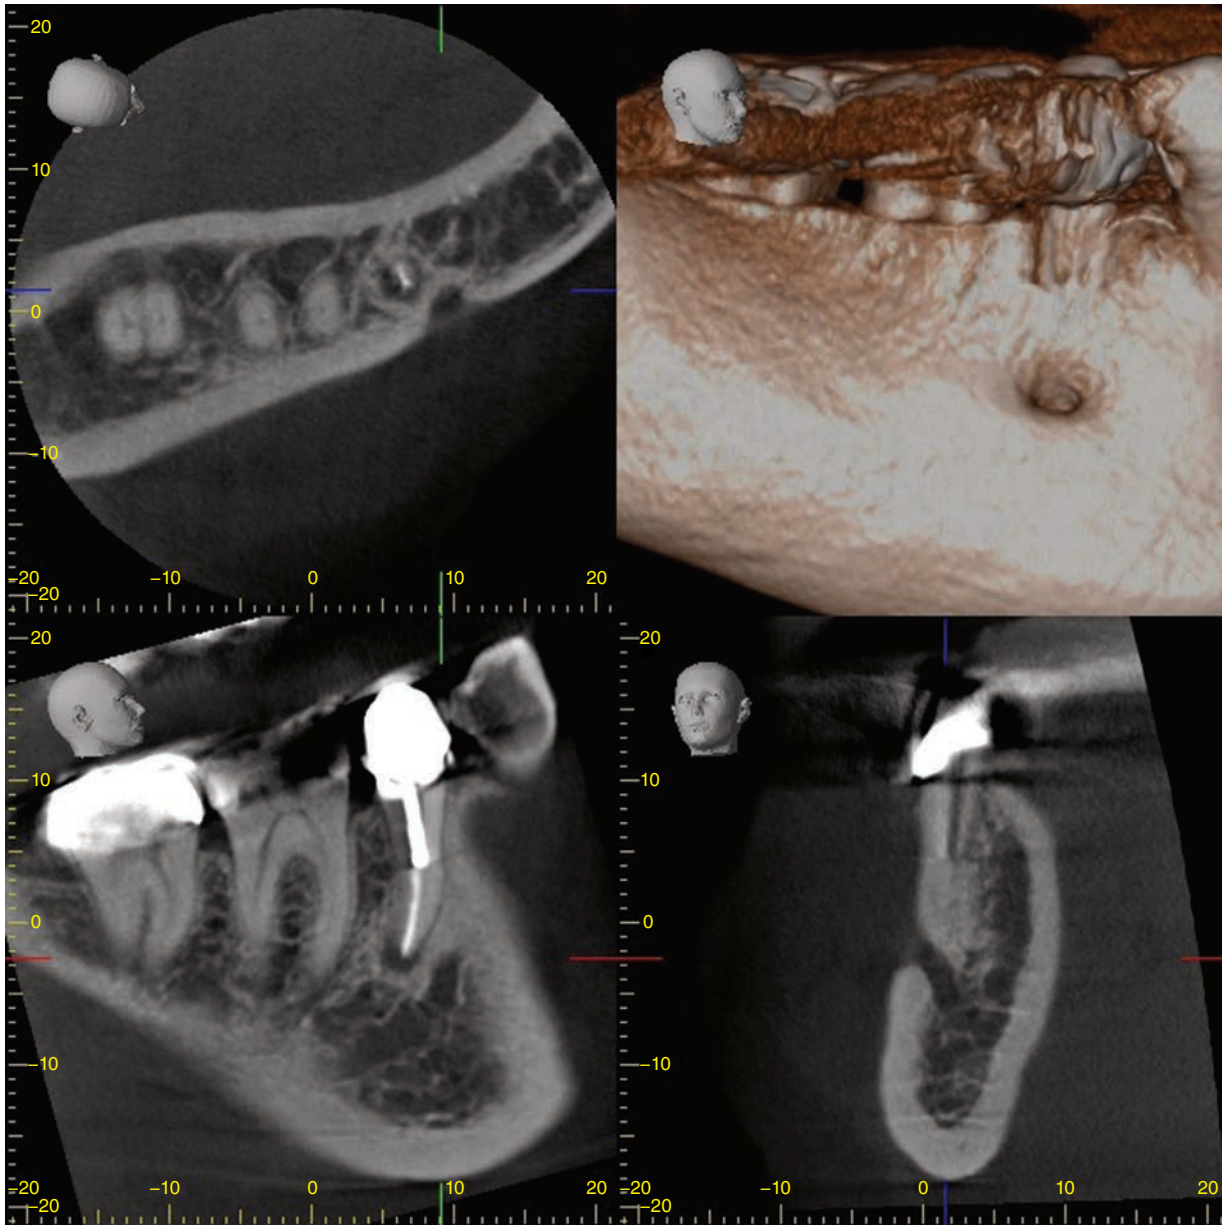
CBCT shows coronal, sagittal, and axial views of the mandibular right posterior area, and a clear view of the mental foramen.
